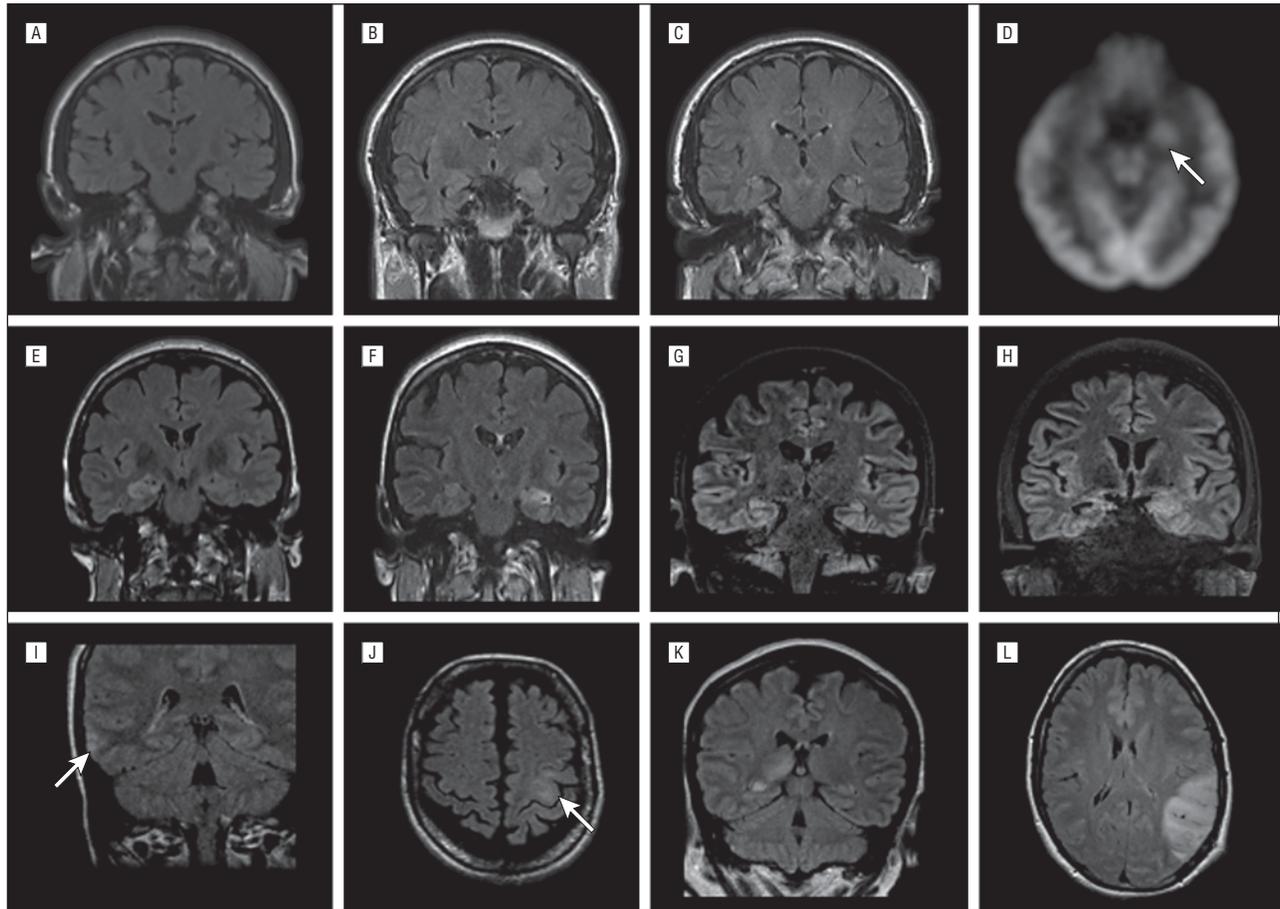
Representative neuroimaging abnormalities and evolution. Patient 18 presented with a 10-month history of daily episodes of complex partial seizures. Despite normal magnetic resonance imaging (MRI) findings at presentation (A), subsequent preimmunotherapy MRI performed 9 months after seizure onset revealed left amygdala swelling (B) and bilateral hippocampal hyperintensity and atrophy (C). Radiolabeled fluorodeoxyglucose positron emission tomography brain scan showed hypermetabolism within the left amygdala (D) (arrow). Patient 27 had a 4-month history of daily complex partial seizures. Brain MRI revealed T2 hyperintensity within the right amygdalohippocampal region 3 months following seizure onset (E), which evolved to include the contralateral region 2 months later (F). Repeated MRI 3 months later before immunotherapy initiation demonstrated radiographic evidence of bilateral mesial temporal sclerosis (G) and residual left amygdala swelling and hyperintensity (H). Patient 3 presented with partial and secondary generalized seizures. There was signal abnormality in the right lateral temporal lobe (I) (arrow) after her first generalized tonic-clonic seizure, which occurred several weeks after the onset of partial seizures. Patient 11 was diagnosed with *epilepsia partialis continua* and had abnormal signal in the left precentral gyrus (arrow) 2 months after seizure onset (J). Patient 7 developed status epilepticus after a 3-month history of complex partial seizures. Admission MRI revealed right thalamic and medial temporal hyperintensities (K). Patient 32 presented with generalized tonic-clonic seizure and subsequently developed antiepileptic drug–intractable aphasic seizures. Presentation MRI demonstrated pronounced signal abnormality in the left frontoparietal region (L).
